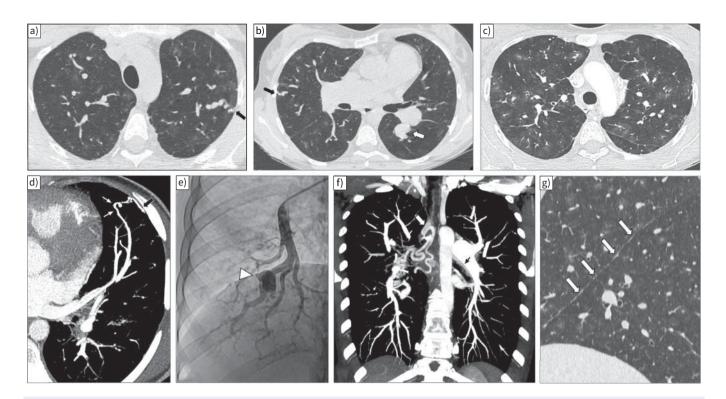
Representative high-resolution computed tomography (HRCT) of the chest, CT pulmonary angiography (CTPA) and pulmonary angiogram of pulmonary arterial hypertension patients carrying a *SOX17* pathogenic variant. a–c) Thin-collimated HRCT of the chest showing a) subpleural dilated and b) tortuous pulmonary vessels (black arrows) and c) ground-glass opacities. d) The black arrow points to direct communication between a dilated distal pulmonary artery and a dilated intercostal artery. b, e) Aneurysmal dilatation identified on b) CTPA (white arrow) and e) pulmonary angiography (arrowhead). f) Marked dilatation of proximal bronchial arteries is frequently observed (white and black arrows). g) The presence of numerous fissural irregularities (white arrows) suggests the additional presence of dilated systemic vessels at the pleural surface.
